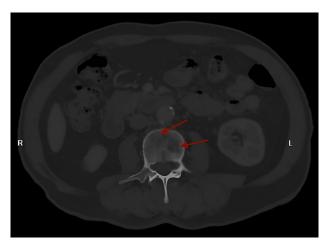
Single axial CT scan in the bone window setting showing an osteolytic lesion within the vertebral body, suggestive of metastatic involvement from breast cancer (red arrows).
